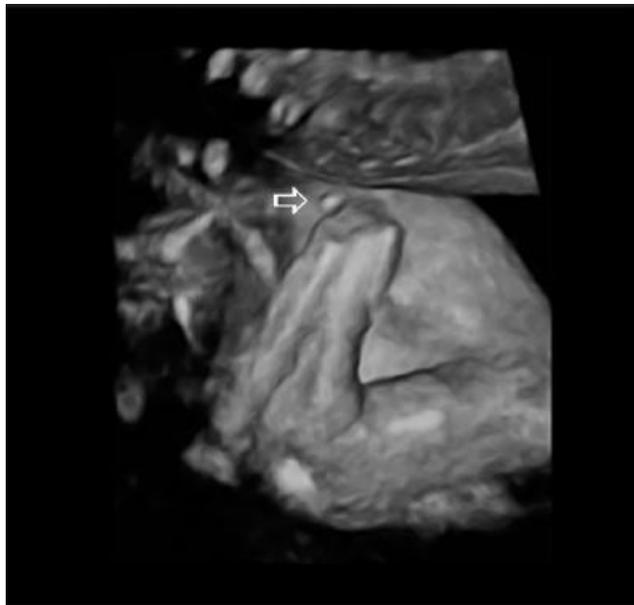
3D ultrasound (27 wk) pointing small vestige at site of amputation.
